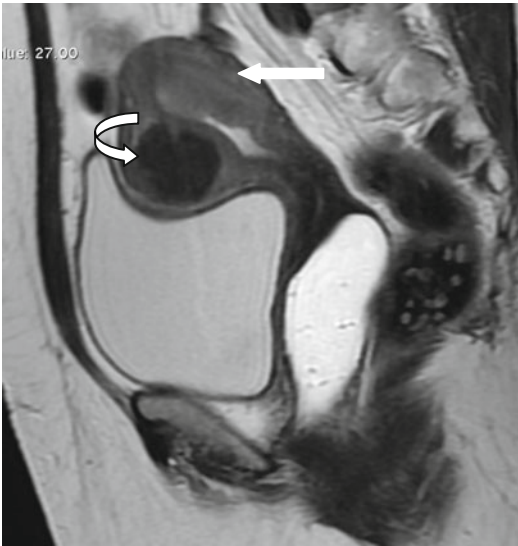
63-year-old lady with postmenopausal bleed, T2 sagittal and axial MRI showing mass in the endometrial cavity infiltrating the myometrium (*straight arrow*). An anterior wall fibroid is also noted (*curved arrow*)
